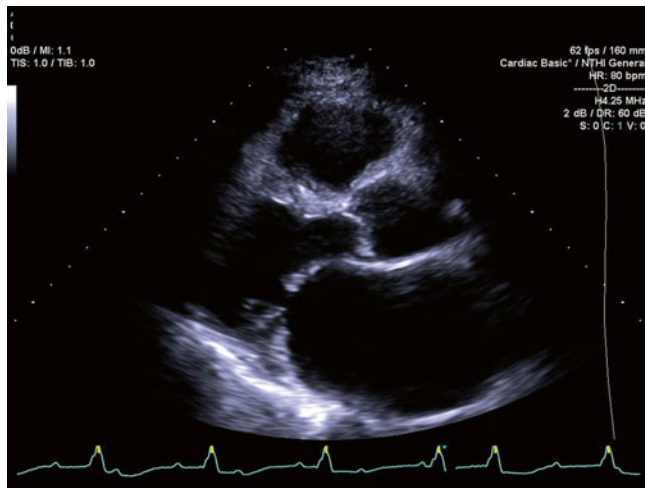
Parasternal long axis echocardiographic view on a 55 year old man with long standing HCM who developed LV systolic dysfunction (LVEF 25 %), LV cavity enlargement and wall thinning, and progressive heart failure symptoms. Despite all medical therapies he progressed to class IV heart failure symptoms, underwent LVAD placement, and was successfully bridged to transplantation. LV size is mildly increased when adjusted for body surface area and larger than on previous echocardiograms. Septal thickness is at the upper limits of normal and the left atrium is severely enlarged
